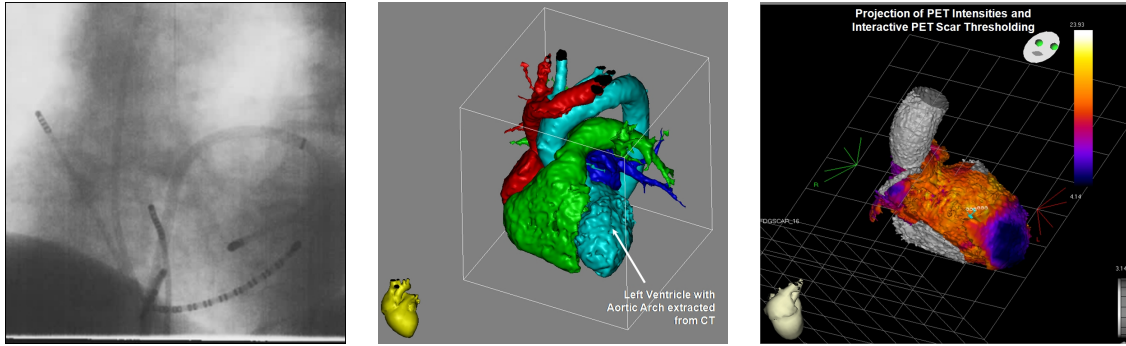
Typical images available during interventional VT ablation therapy. Original fluoroscopic x-ray image (left) that was previously used to perform ablation therapy on the heart. Images currently employed during ablation showing (middle) 3-d segmentation of the heart from CT and (right) PET intensity information projected onto the segmentation from CT.
